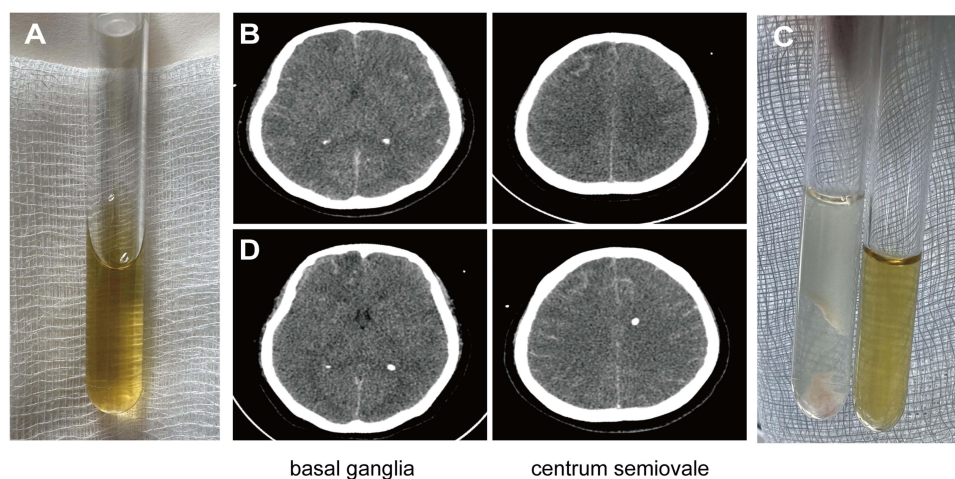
CSF profiles and brain CT findings at different time points. (A) On the morning of June 8, the CSF was light yellow and slightly turbid. (B) On the afternoon of June 8, the cranial CT scan showed decreased density of the brain parenchyma, narrowed ventricles and sulci, indicating diffuse brain swelling. Left: Basal ganglia level; Right: Centrum semiovale level. (C) On June 10, the cerebrospinal fluid was collected again, which was more turbid than before. (D) On the June 9, the postoperative cranial CT suggested that the brain tissue swelling is still severe, and the left EVD tube can be seen. Left: Basal ganglia level; Right: Centrum semiovale level.
